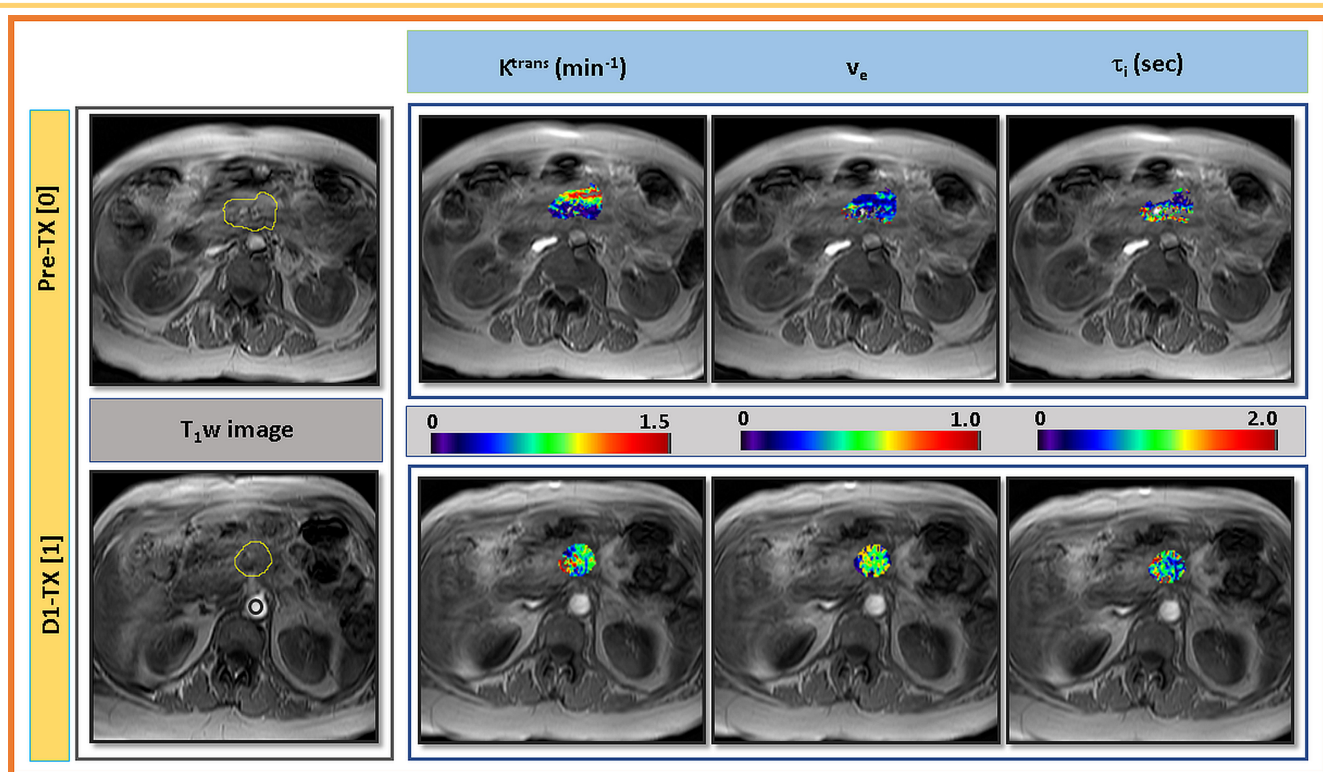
Left: Representative T1-weighted (T1w) images at pre-treatment (TX[0]) and immediately after the first fraction of stereotactic body radiotherapy, D1-TX[1], from a patient who showed a local control (61 years, female). ROIs were drawn on the pancreatic tumor (outlined in yellow color) and aorta (outlined in red circle) for the plasma contrast agent concentration, C_p . Right: Representative SSM-derived parametric maps of K^{trans} , v_e , and τ_i overlaid on T1w image at longitudinal MR examinations (ie, pre-TX[0] and D1-TX[1]). An increase in quantitative metrics value after the first fraction of SBRT is evident.
